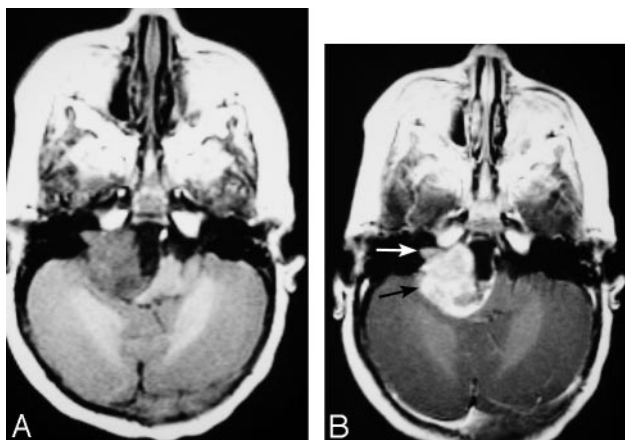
MR images of a 10-month-old female infant with an extra-axial AT/RT in the right cerebellopontine angle cistern, extending into the right internal auditory canal (arrows).
